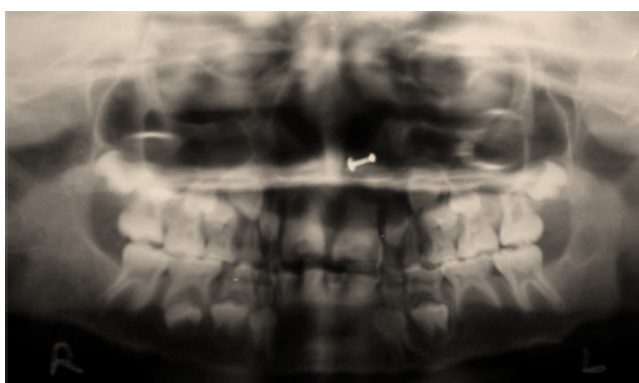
Orthopantomogram (Case 1)
